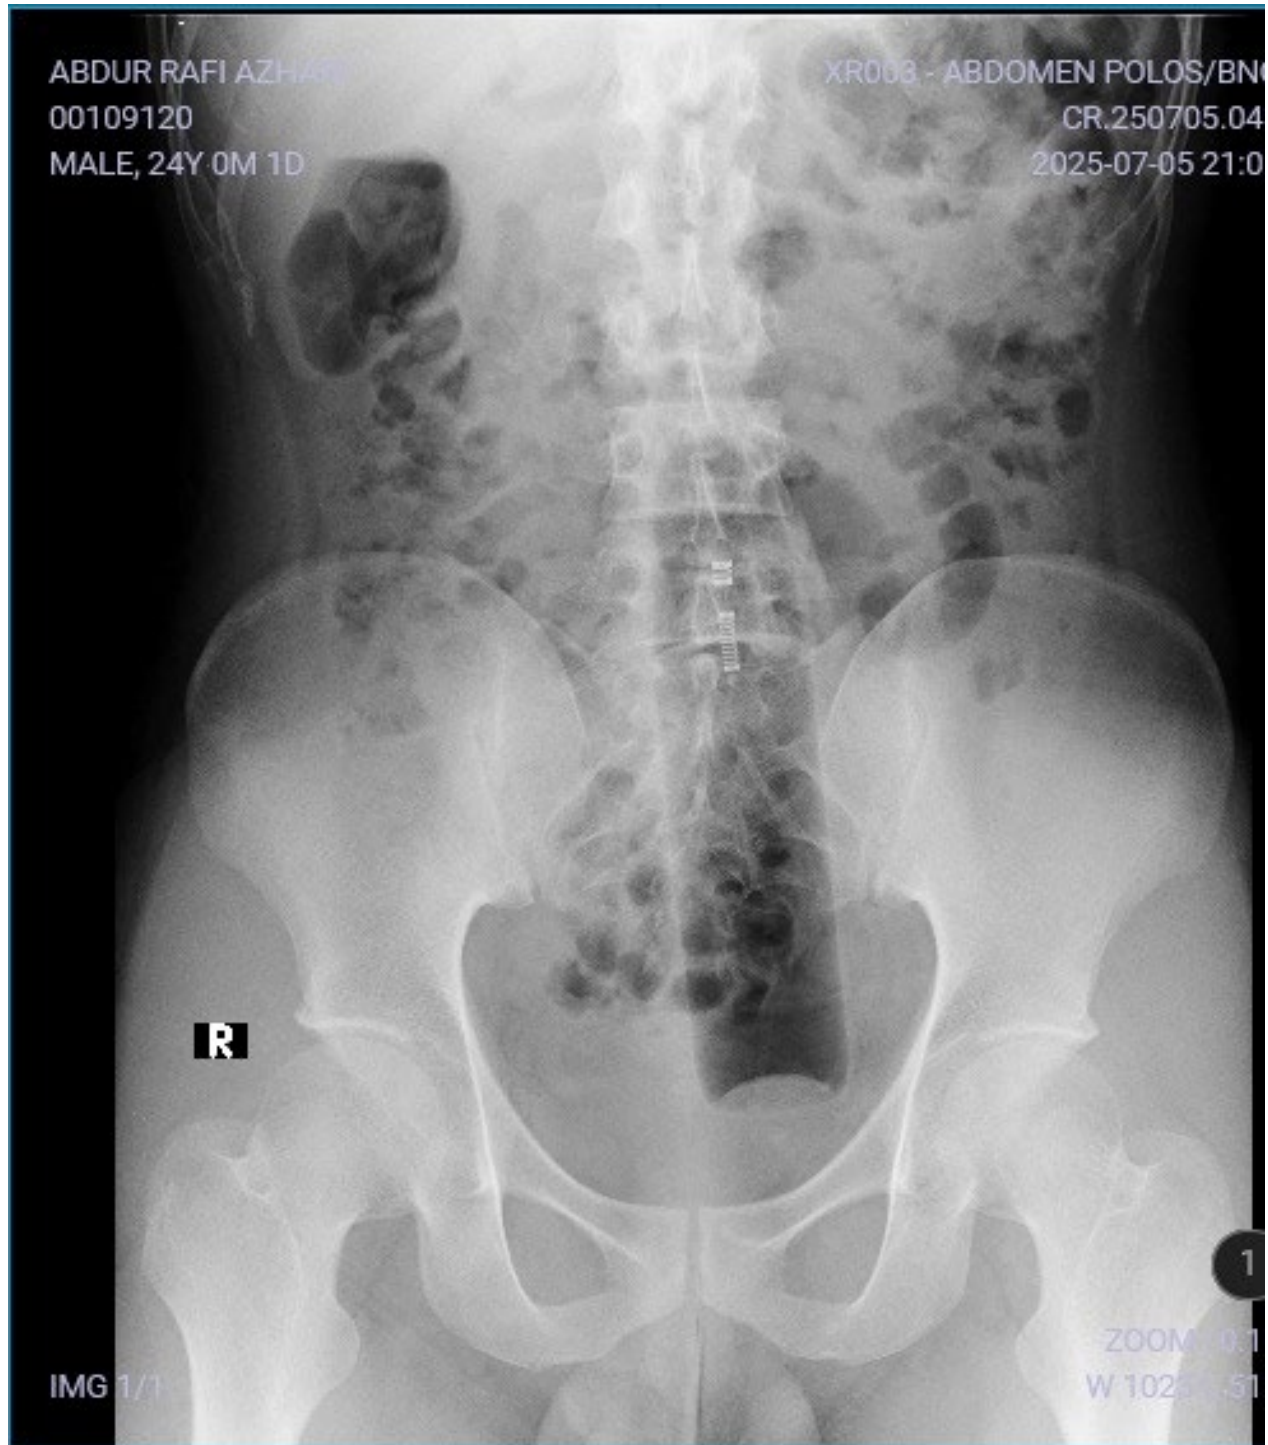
Abdominal AP Radiography (BNO)
